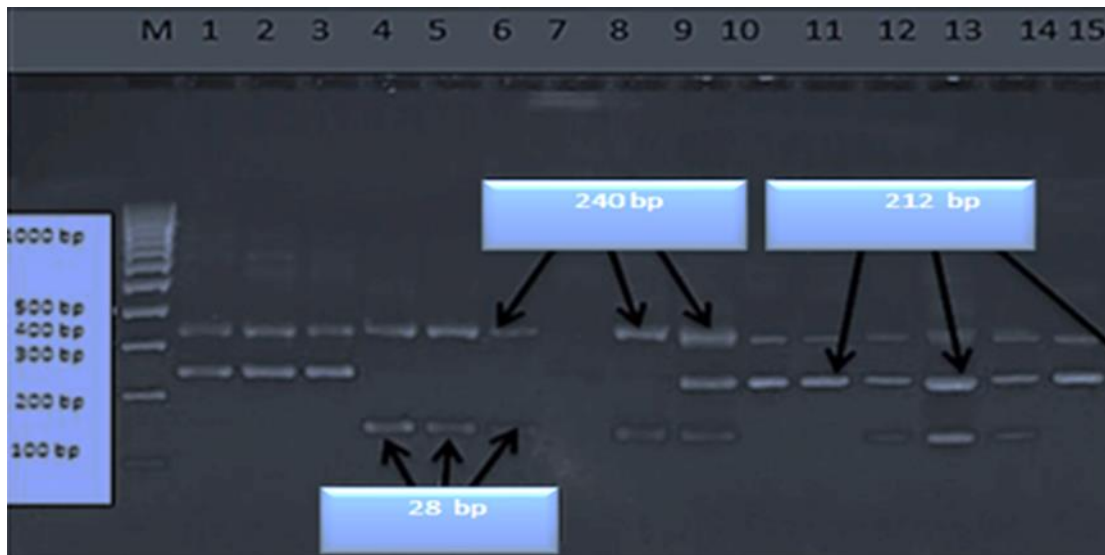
Electrophoretic pictures represents the genotypes, CC, CT, and TT C>T rs705379 SNP of PON1 gene
